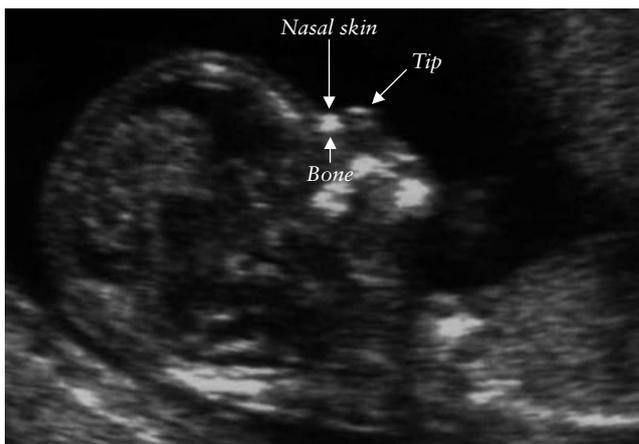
Ultrasound image showing the two parallel horizontal echogenic lines in the nose, the top one representing the skin and the bottom one representing the nasal bone and cartilage. A third line, almost continuous with the skin, but at a higher level, represents the tip of the nose.
